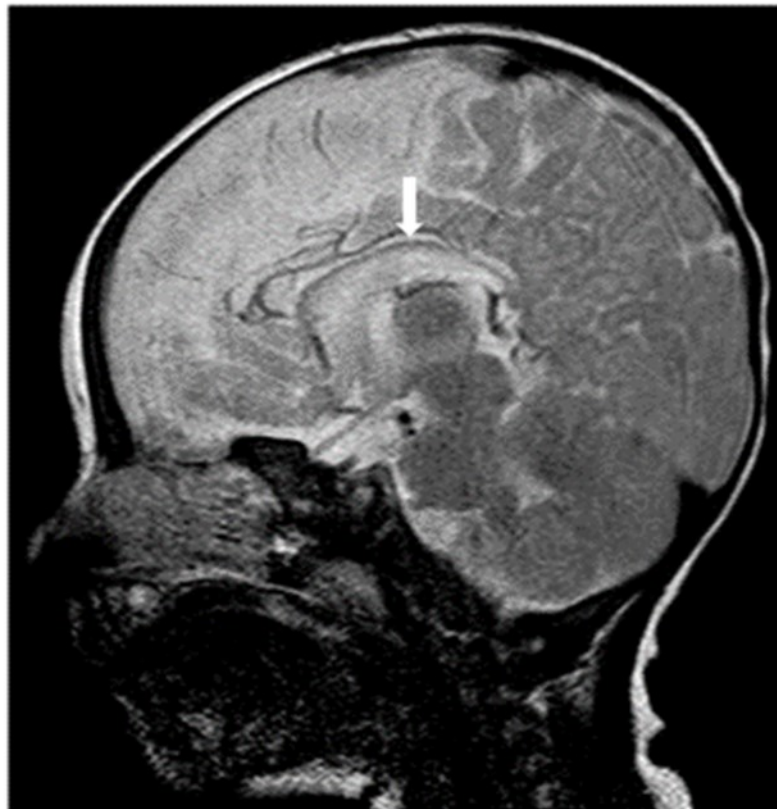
Midline sagittal T2-weighted magnetic resonance image of the patient showing diffuse hypoplasia of the corpus callosum.
